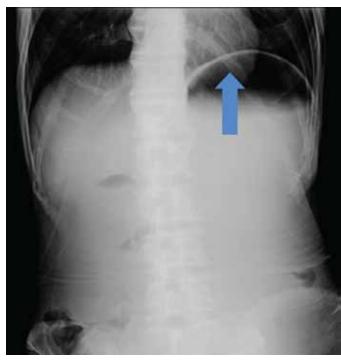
Supine abdominal X-ray showing grossly distended stomach (arrow) and paucity of gas distally in collapsed bowel.
